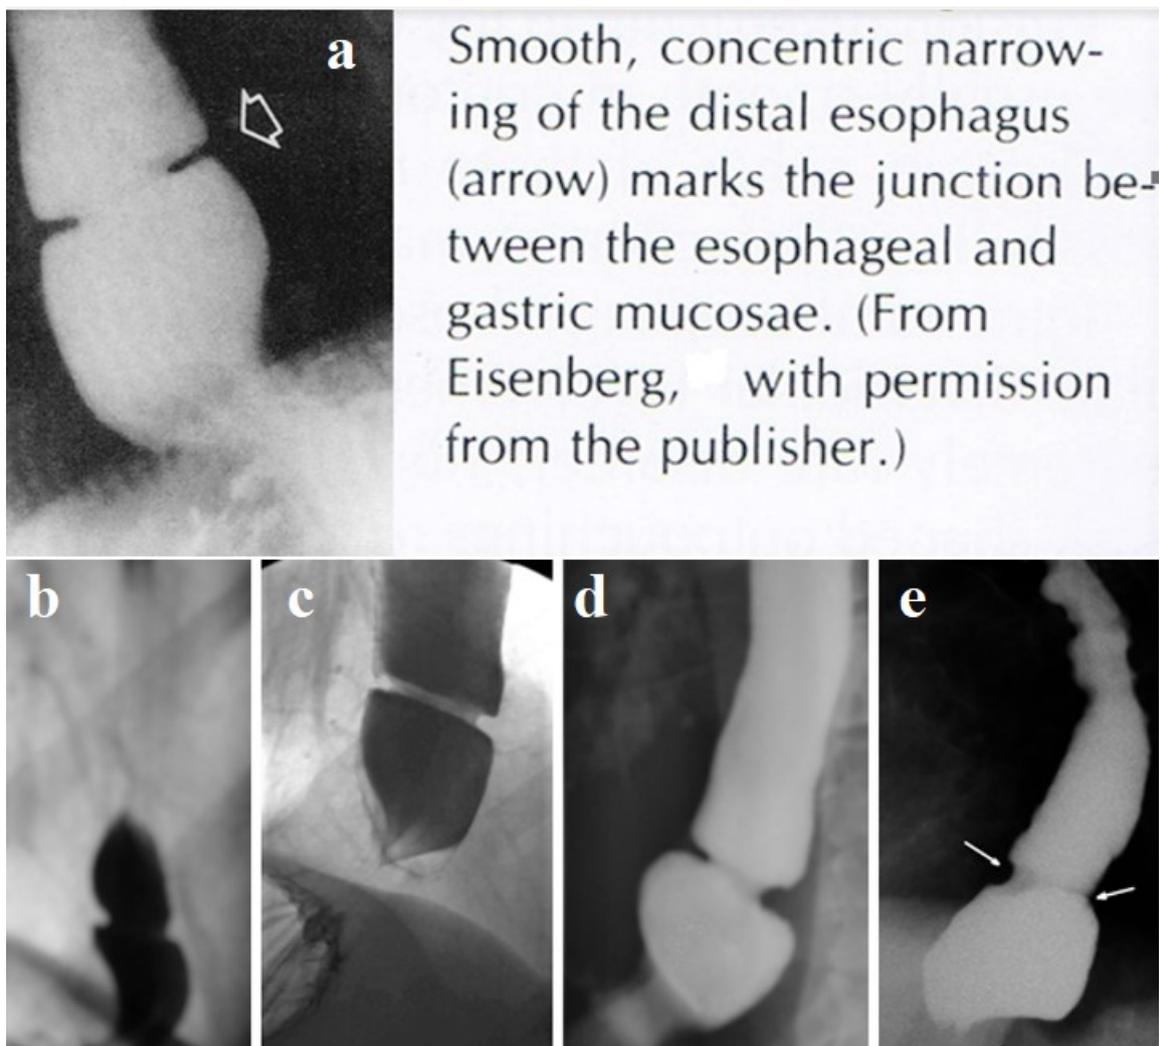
Five radiographs with lower esophageal ring. (A-C) correspond to the description of SR. (D-E) These were 2 (9%) cases recognized as doubtful due to asymmetry in the thickness of the ring and phrenic ampulla.
